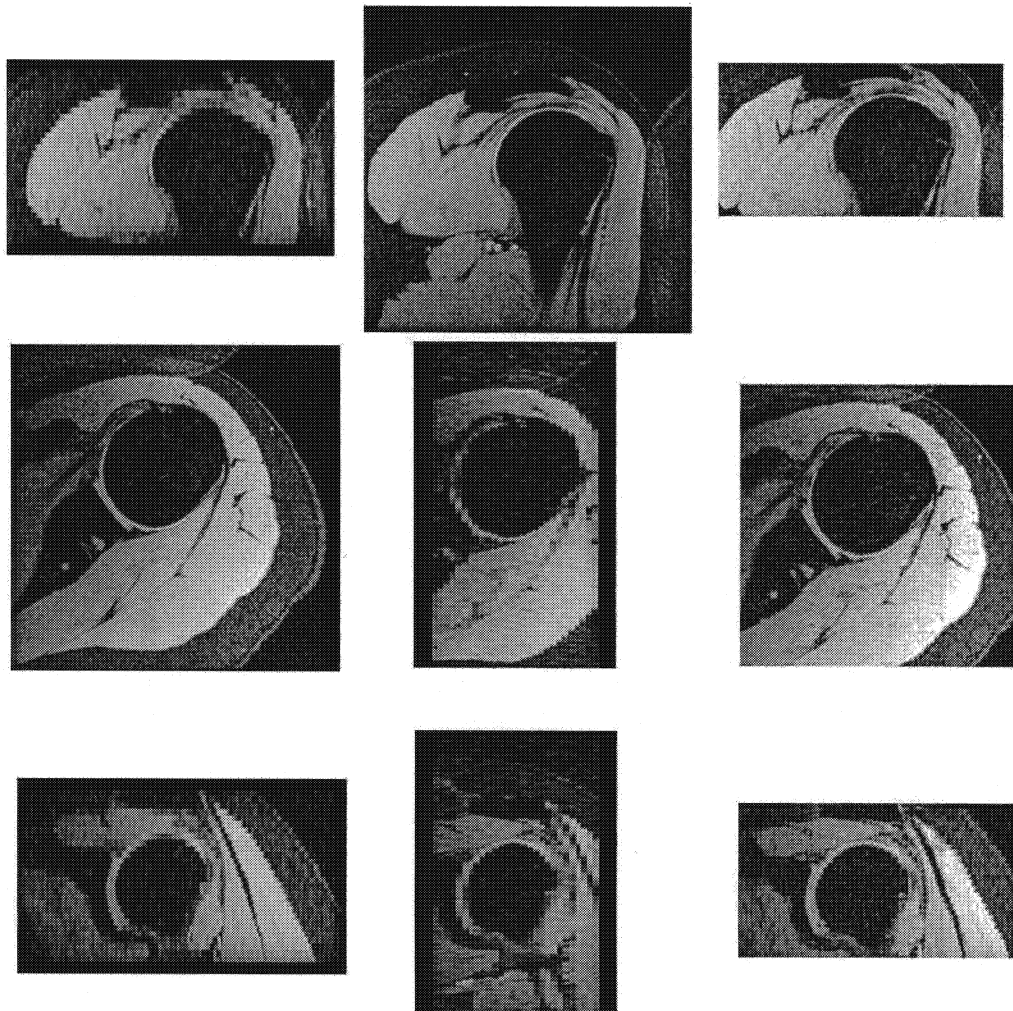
(a) axial, (b) sagittal, (c) coronal views of the original MRI sagittal scan (left images) and axial scan (central images) and the fused image (right images) of a human shoulder.
